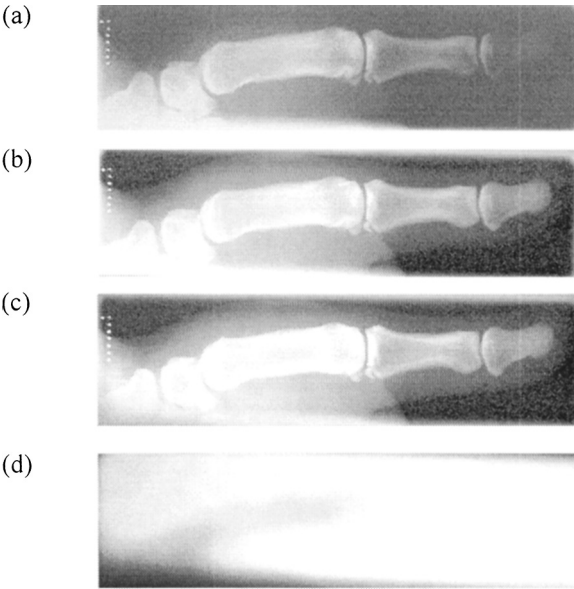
Radiograph of a thumb with (a) no masking, (b) edge masked only and (c) fully masked using the mask in (d).
